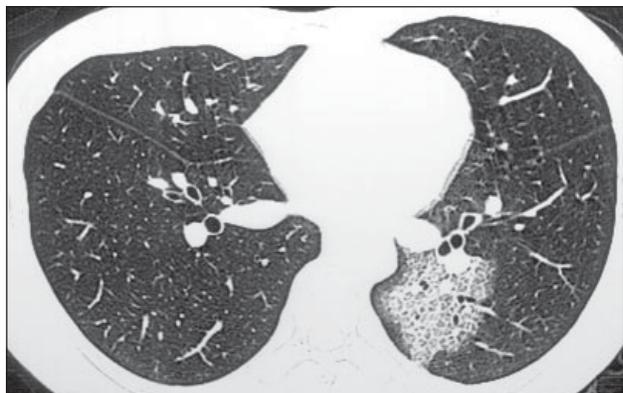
High-resolution computed tomography of a 37-year-old patient with severe acute respiratory syndrome showing an area of ground glass opacification in the peripheral portion of the apical segment of the left lower lobe.
